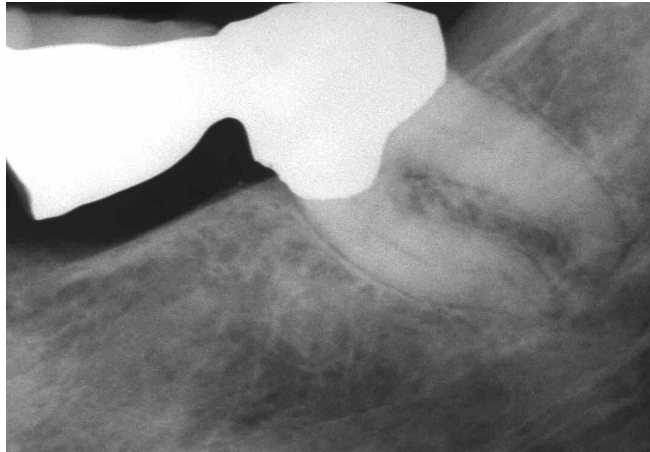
This radiographic image reveals an endodontically-involved posterior bridge abutment. Note the orientation of the prosthesis to the underlying roots.
